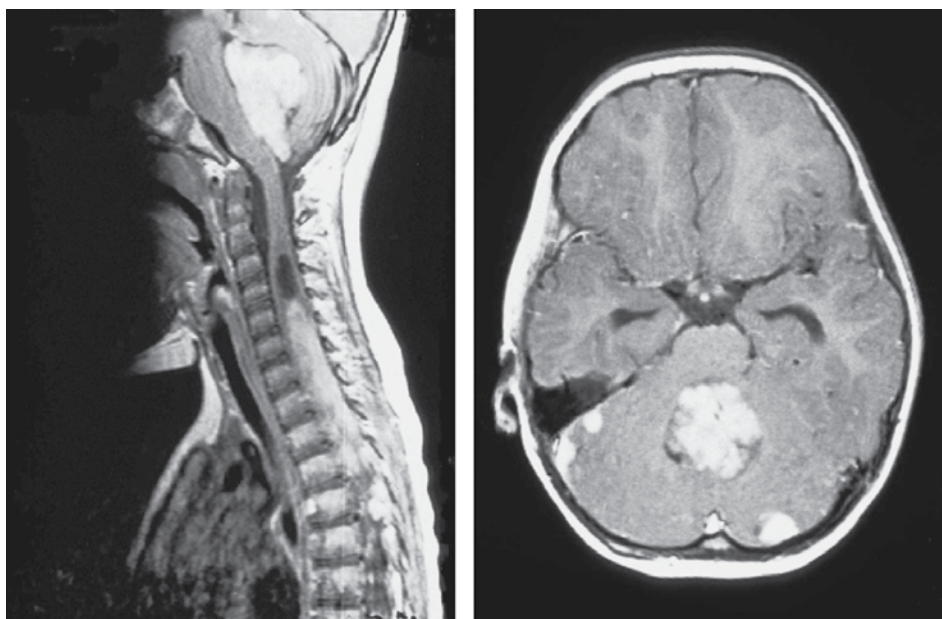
Medulloblastoma with metastatic spread to the meninges within the posterior fossa and with a large intramedullary deposit. Sagittal and axial MRI, T1 weighted Gadolinium contrast enhancement.
